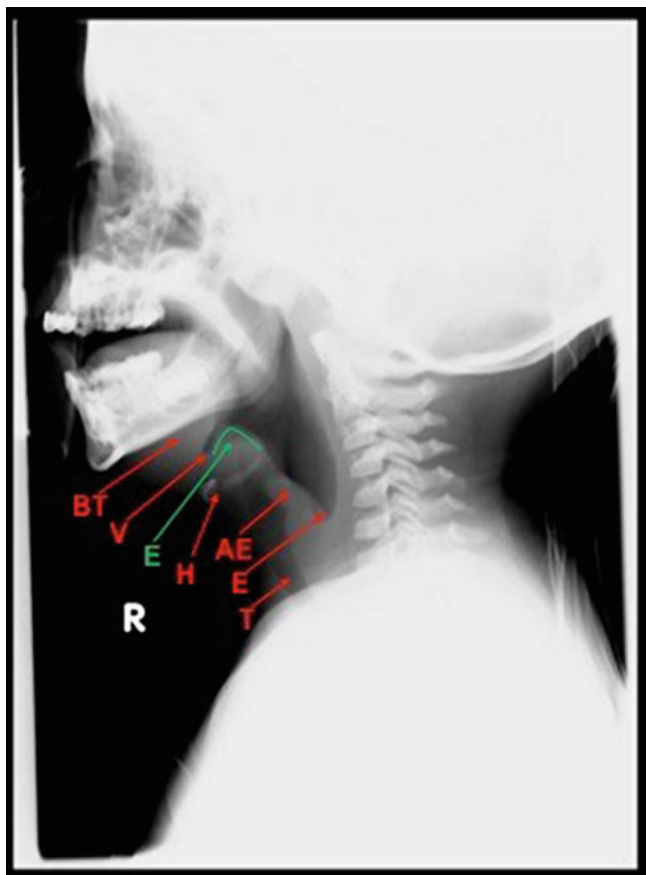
Lateral neck radiograph. Base of the tongue (BT), vallecula (V), epiglottis with thumb sign (E), hyoid (H), edematous aryepiglottic folds (AE), esophagus (E), and trachea (T)
